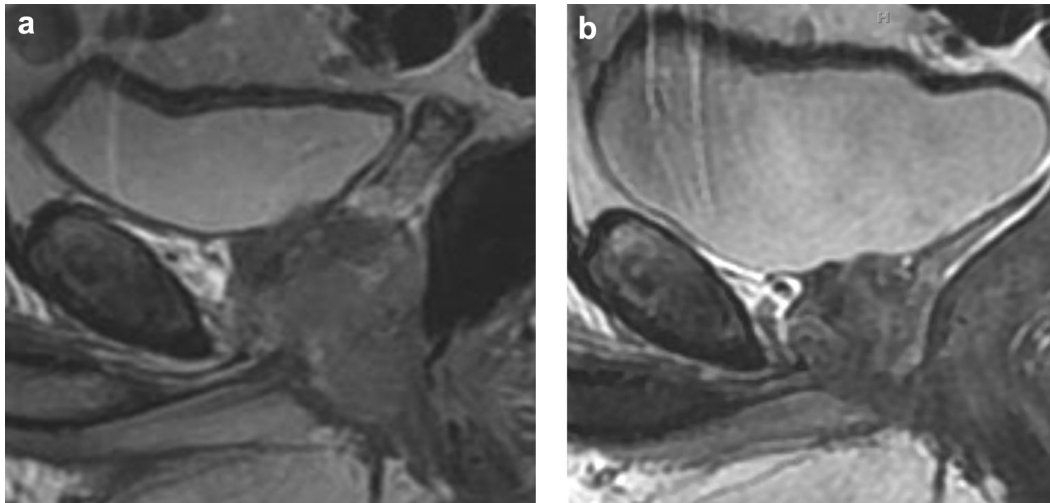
T2 weighted sagittal MRI images demonstrating local effect of ADT. (a) Image taken prior to ADT demonstrating tumor extension below the penile bulb. (b) Image taken post-ADT demonstrating shrinkage of disease.
